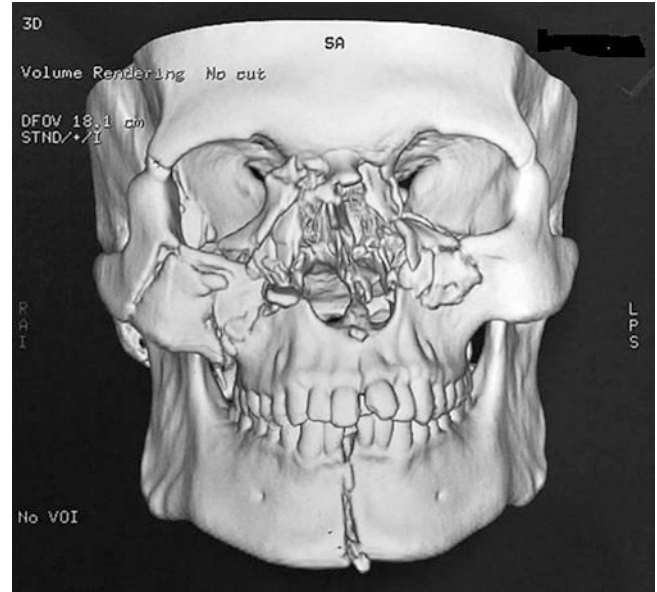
3D reconstructed, volume-rendered CT scan of facial skeleton showing an extensive NOE fracture along with bony lacrimal involvement
